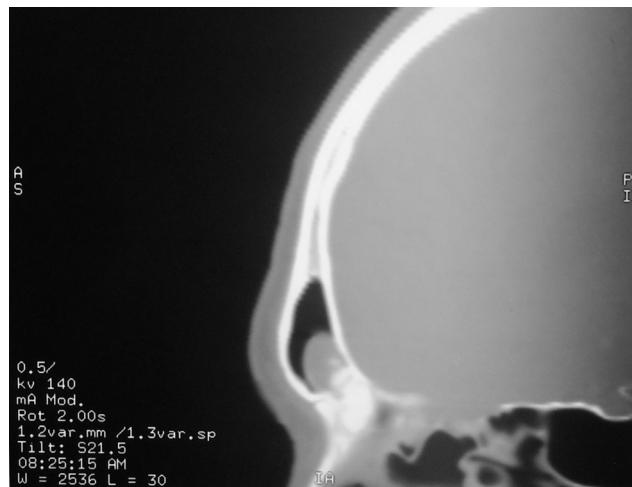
Sagittal CT scan showing the frontal recess tumour and a cyst behind
